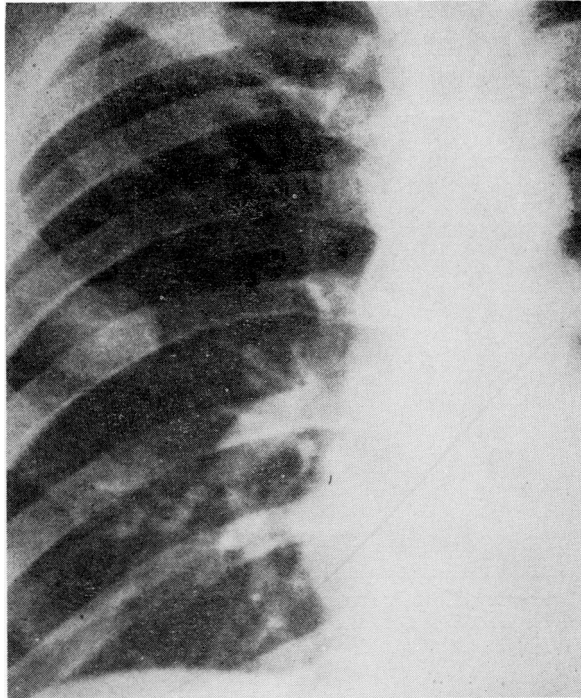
Roentgenogram, Case 4. Coin lesion showing slightly flattened shape of the tumor, which measured 2.5×3 cm. after resection.
